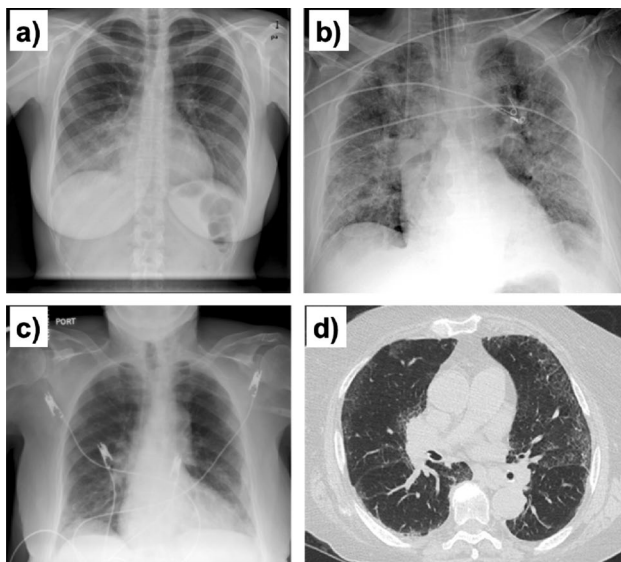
X-rays and CT scan cases from a new unseen COVID-19 Repository (<https://cortex.acr.org/COVID19/>). a Case number 59,638: chest X-ray of a 29-year-old immunocompromised female patient with a 3-day history of cough and fever. Past medical history includes severe ulcerative colitis treated with tofacitinib. b Chest X-ray of case number 59,554 presented to emergency department with respiratory distress and dyspnea. c Chest X-ray of the case number 56,442 with a history of shortness of breath and cough, and recent international travel with someone who tested positive for COVID-19. d CT scan of the case number 56,442
